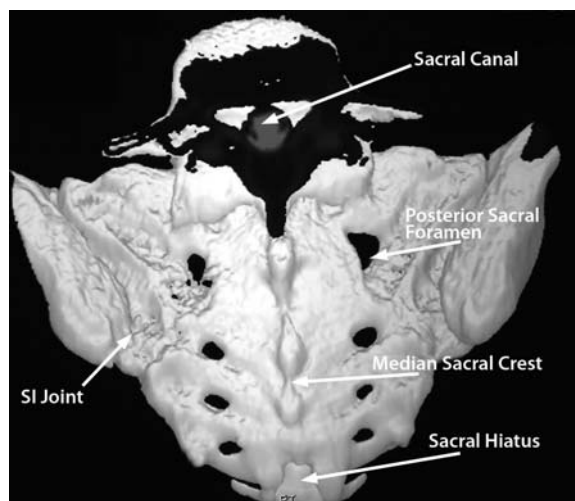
Three-dimensional CT reformation demonstrating a posterior view of the sacral anatomy
